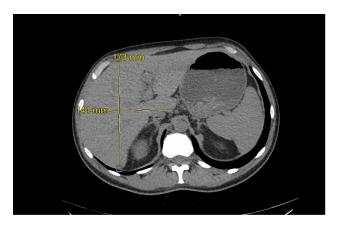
The CT abdomen axial view shows hepatomegaly measuring 173 mm x 141 mm
